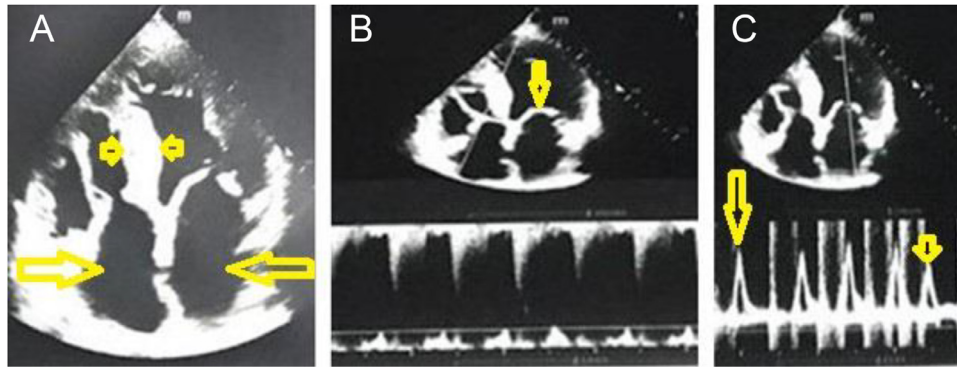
Echocardiography selected images (A and B) 4-chamber views showing increased LV septal wall thickness (arrow head on [A]), biatrial dilation (thick arrows on [A]), and valvular thickening are shown (arrows on [B]). (C) Pulsed wave Doppler of the mitral inflow: Mitral inflow demonstrates a high E-wave velocity (long arrow) with a small A-wave velocity, $E/A > 2$, and short deceleration time of 100 msec (short arrow).
